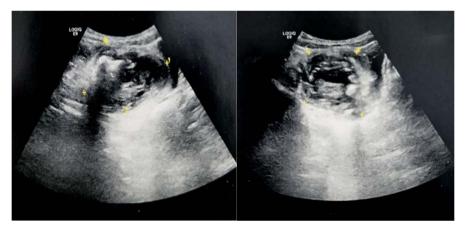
Ultrasound appearance: heterogeneous right latero-uterine tissue mass. (*) represents mass.
